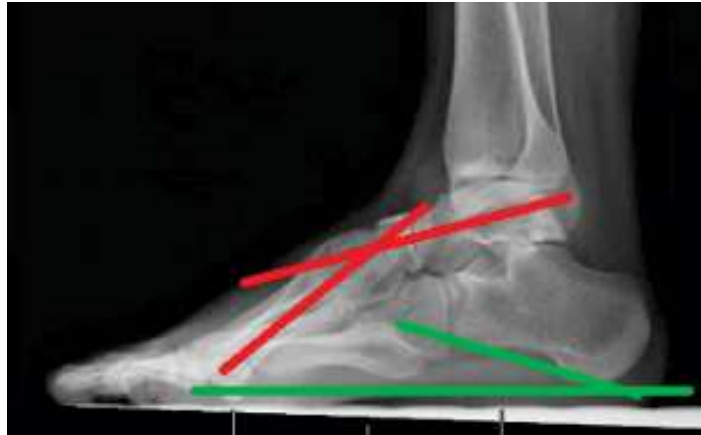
Pes Cavus on lateral standing x-ray. Meary's angle (red) and the calcaneal pitch angle, between the long axis of the calcaneus and the bottom of the foot (green), are shown.
